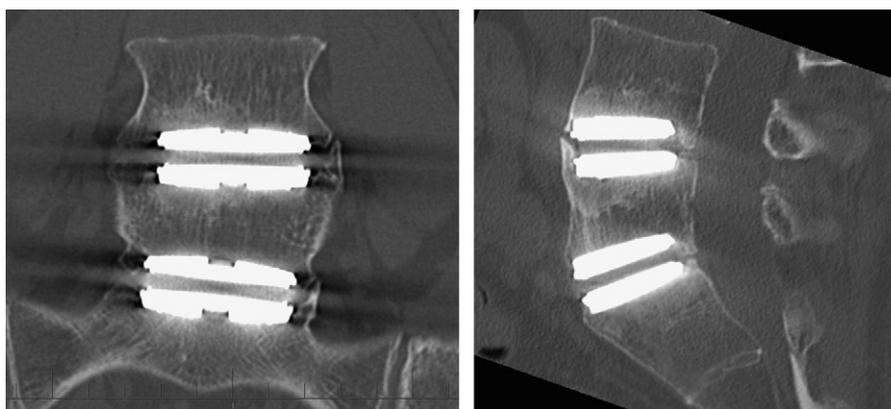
(Left) Coronal and (Right) sagittal computed tomography scans from one 48-year-old male (Pilot 2) with a two-level AcroFlex lumbar disc replacement in situ. Note the extensive heterotopic bone formation (white arrows) at both levels.
